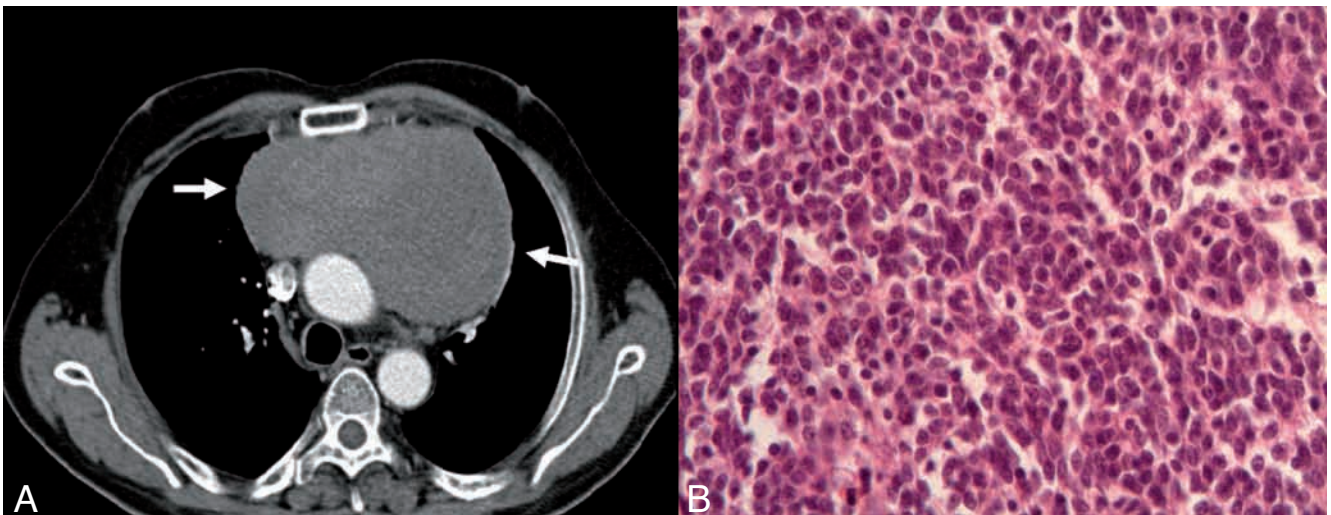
Thymic carcinoid. A 59 year old man logs on to the emergency department because of chest pain, chronic cough and weight loss. Thoracic CT shows a large voluminous inhomogeneous solid mass with a diameter of 16 × 9 cm. There are no calcifications, cystic necrotic areas, invasion of vascular structures and no pathologically adenopathies (*arrow*).
